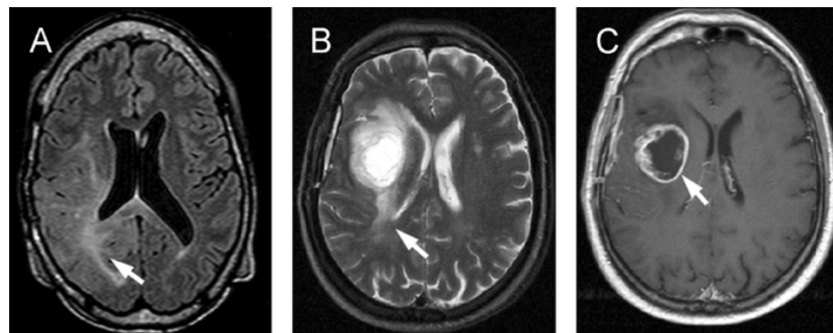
Examples MRI images of GBM. Anaplastic astrocytoma (AA, WHO Grade III) and GBM (WHO grade IV) have distinct growth patterns as demonstrated on magnetic resonance imaging (MRI). (A) Axial MRI of AA shows expansion of the involved brain and increased signal intensity on FLAIR imaging, reflecting the vasogenic edema that arises in response to infiltrating tumor cells (white arrow). After the administration of contrast agents, most AAs demonstrate modest or no enhancement resulting from an intact blood-brain barrier and a lack of central necrosis. (B) Axial MRI of GBM also demonstrates hyperintense regions at the tumor periphery on T2-weighted imaging, indicative of diffusely infiltrating cells (white arrow). (C) A distinguishing feature is the emergence of a central contrast-enhancing component, which contains a necrotic center and a leading edge that rapidly expands outward (white arrow).³⁷ J Neuropathol Exp Neurol | Copyright © 2006 by the American Association of Neuropathologists, Inc.
